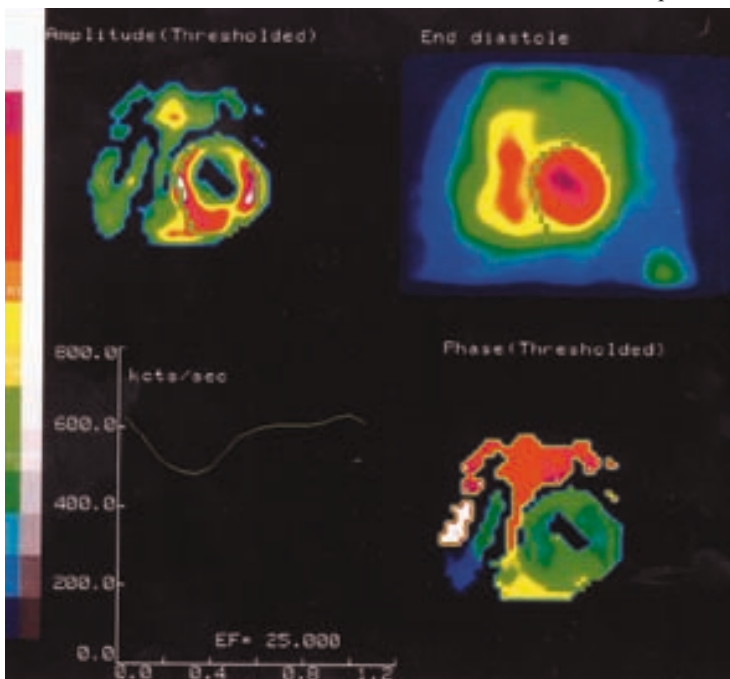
A 60-year-old man had chronic airways disease but no history of coronary artery disease. He presented with a 6-month history of increasing exertional dyspnoea. Echocardiography was suboptimal because of his airways disease. Equilibrium radionuclide ventriculography was performed. The end diastolic image shows a dilated left ventricle (LV) with a normal sized right ventricle. The amplitude image shows a central defect over the LV and the phase image is normal over the LV (the black area is masking of the region with no amplitude). This pattern is typical of extensive inferior akinesis. Resting LV ejection fraction is 25% (normal >45%).
